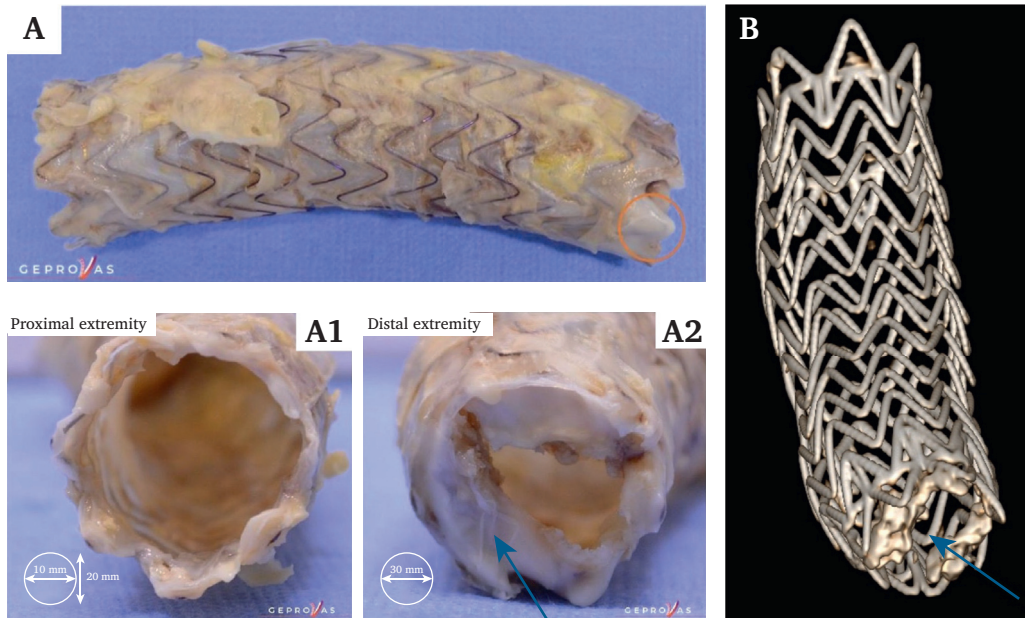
Explant analysis. (A) Macroscopic picture of the explanted device. (A1) The proximal extremity of the endograft. (A2) The distal end with a solid mass attached to the thoracic endovascular aortic repair (TEVAR), highlighted by a blue arrow. (B) 3D microcomputed tomography reconstruction of the explant. The intra-TEVAR calcifications are shown by the blue arrow.
